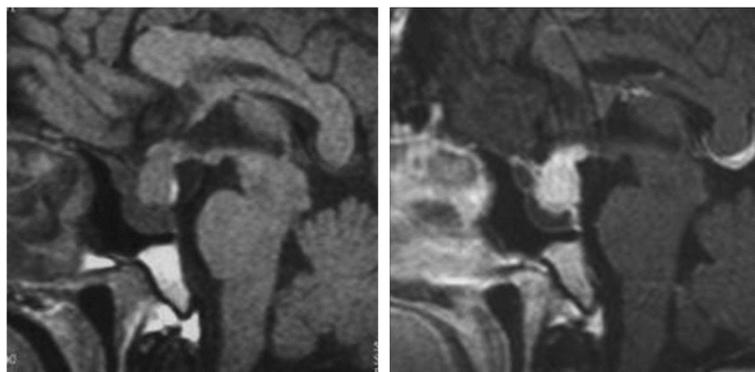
Sagittal T1-weighted (left) and contrast (right): A tumor-like lesion involving the pituitary distinct enhancement up to the suprasellar region. Extension of mass along a thickened pituitary stalk into the hypothalamus
